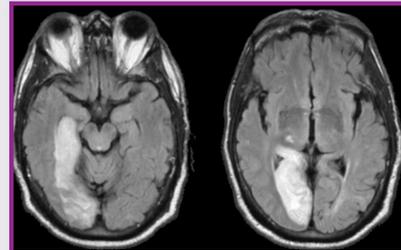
shows two slices of an MR image denoting a large stroke towards the back of the brain.
